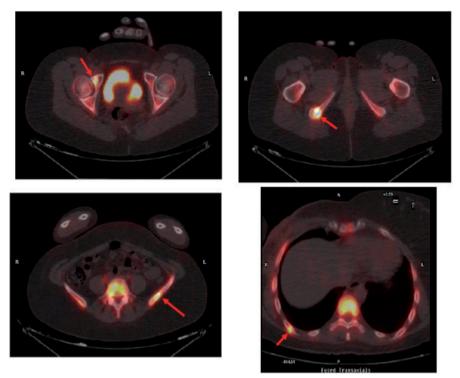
Axial images of the pelvis and chest (right lower images) of a ¹⁸F-sodium fluoride PET/CT scan in a breast cancer patient. The arrows point to osseous metastases not detected on a conventional bone scan done a few days before.
